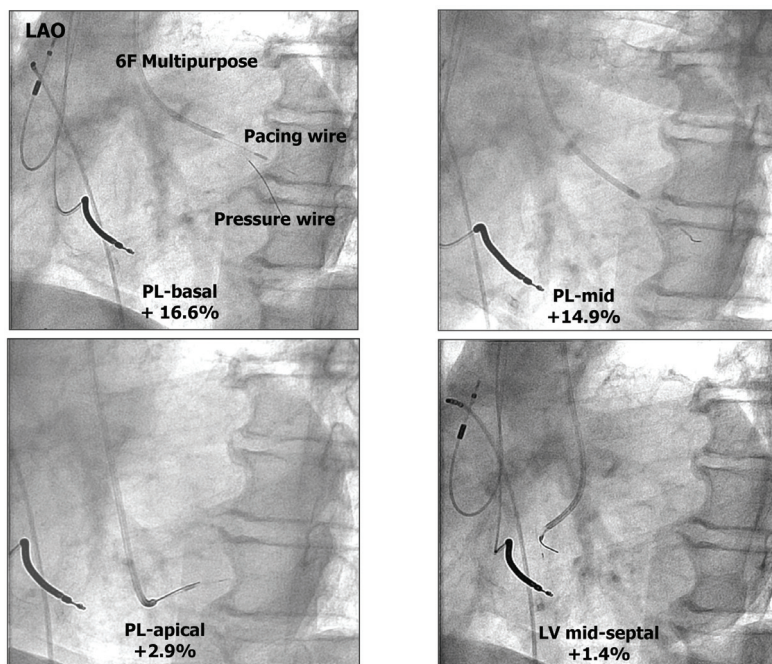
Example of radiographic pictures in a left anterior oblique position of the 4 locations that were hemodynamically tested during the temporary pacing study. The percentage increase in LVdP/dt compared to baseline is mentioned for every position.
